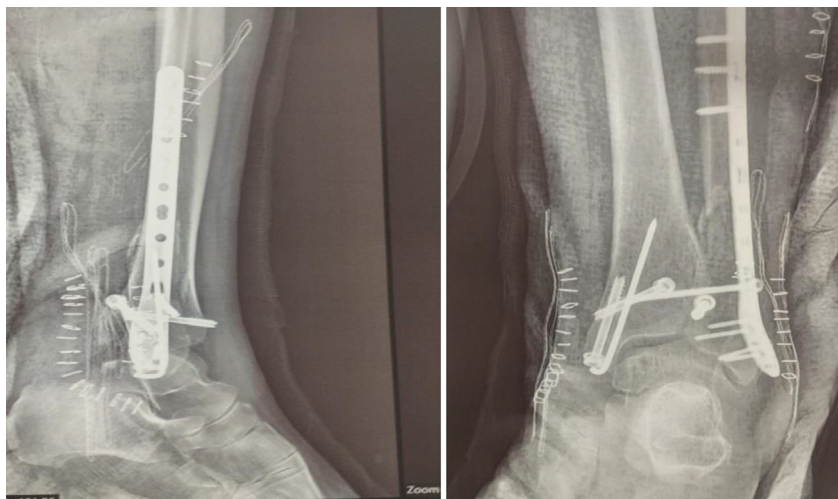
Postoperative radiography AP and lateral.
